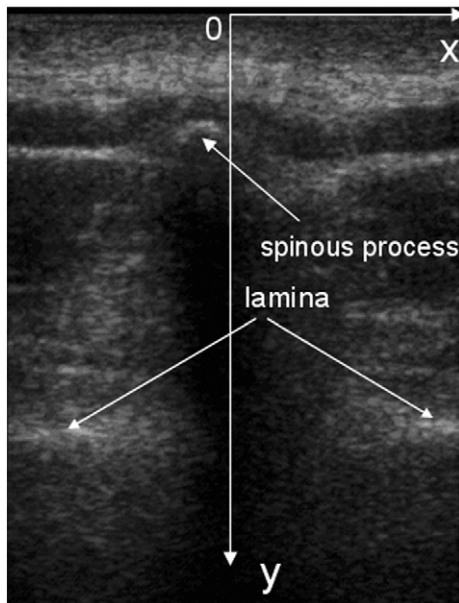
Ultrasound image of a human vertebra. A local coordinate system was defined with its x-y plane aligned with the ultrasound image and its origin located at the center of the upper border of the image.
